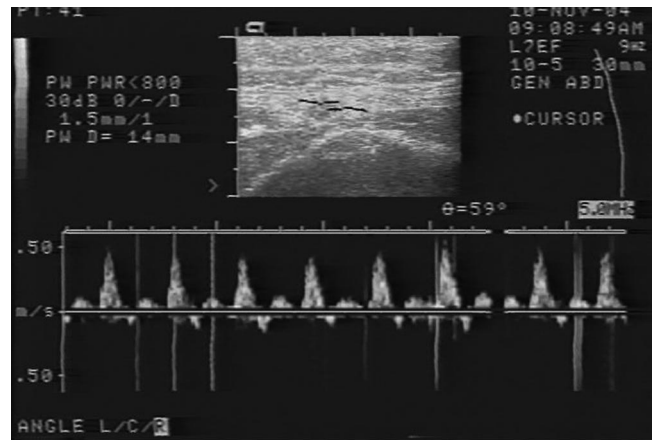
Duplex ultrasound examination of the proximal axillary artery during an 11-s manual flush with a syringe. All blood flow is directed in an antegrade direction toward the ultrasound transducer (above the zero baseline on the Doppler spectral display).
